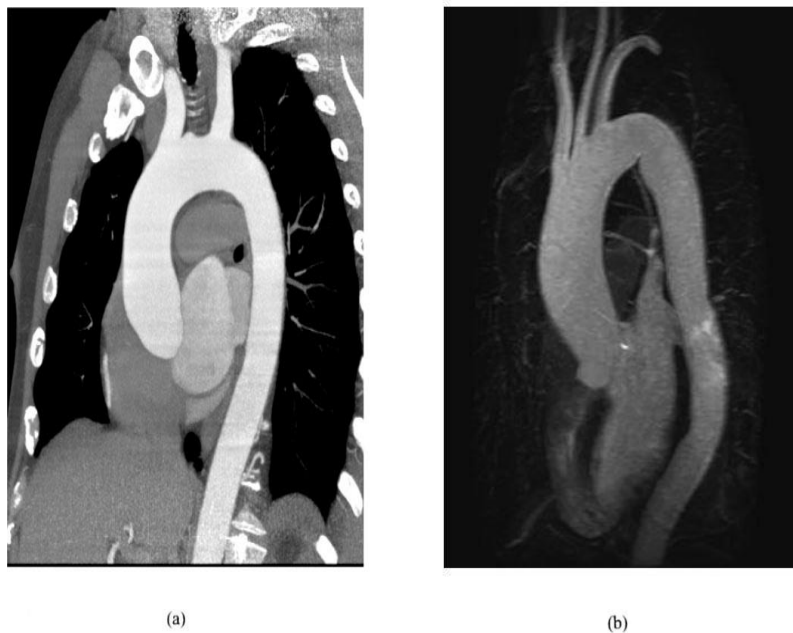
Imaging of the aorta. (a) Aortic reconstruction by CT angiography [42]. (b) Aortic reconstruction by MRA [95].
